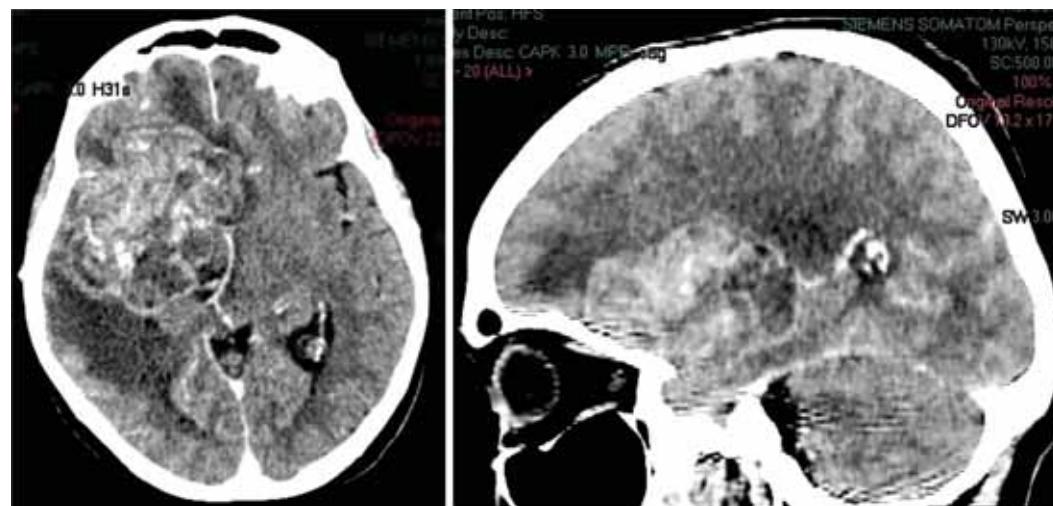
A (left) and 1B (right): Axial and sagittal CT with contrast showing a right fronto-temporal heterogeneous mass, with necrotic areas, with surrounding edema, mass effect and early herniation.
